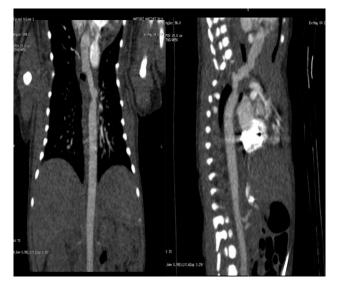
CT: coarctation of aorta.
